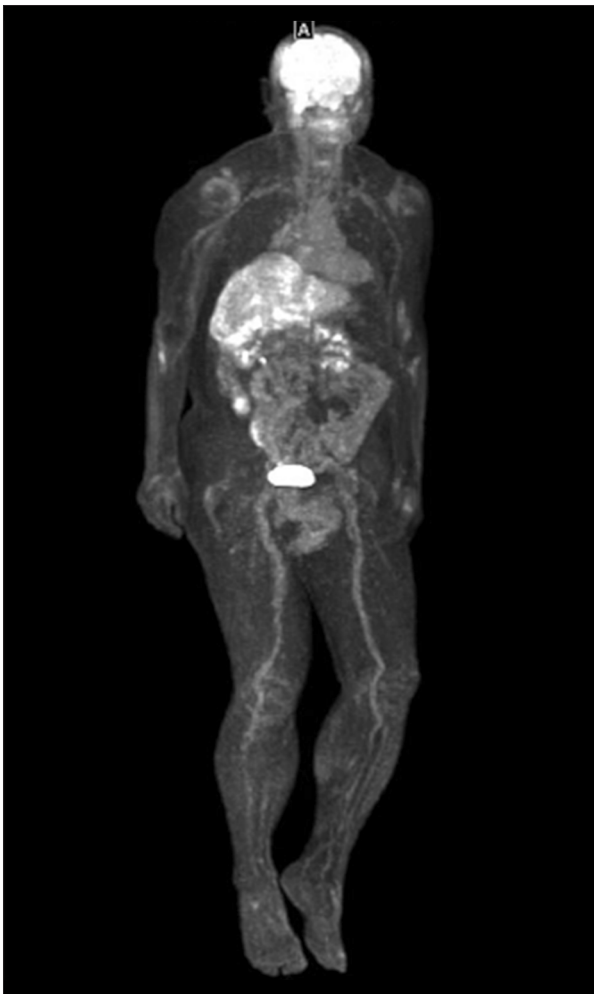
Positron emission tomography-computed tomography (PET/CT) scan (coronal section): the examination was performed for routine follow-up. No abnormal fluorodeoxyglucose (FDG) uptake in osseous structures is noted.
